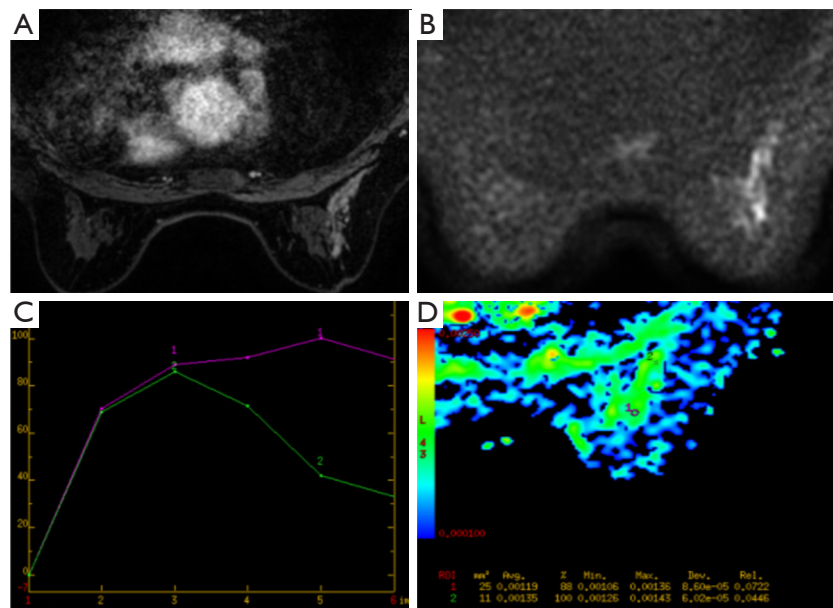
MRI imaging in a 45-year-old woman. (A) Contrast enhanced breast MRI showed segmental distribution and clustered-ring enhancement; (B,C) the lesion showed diffusion restriction on DWI and wash-out dynamic curve; (D) the ADC value of this malignant lesion equals to $1.19 \times 10^{-3} \text{ mm}^2/\text{s}$. Final biopsy showed invasive ductal carcinoma. MRI, magnetic resonance imaging; DWI, diffusion-weighted images; ADC, apparent diffusion coefficient.
